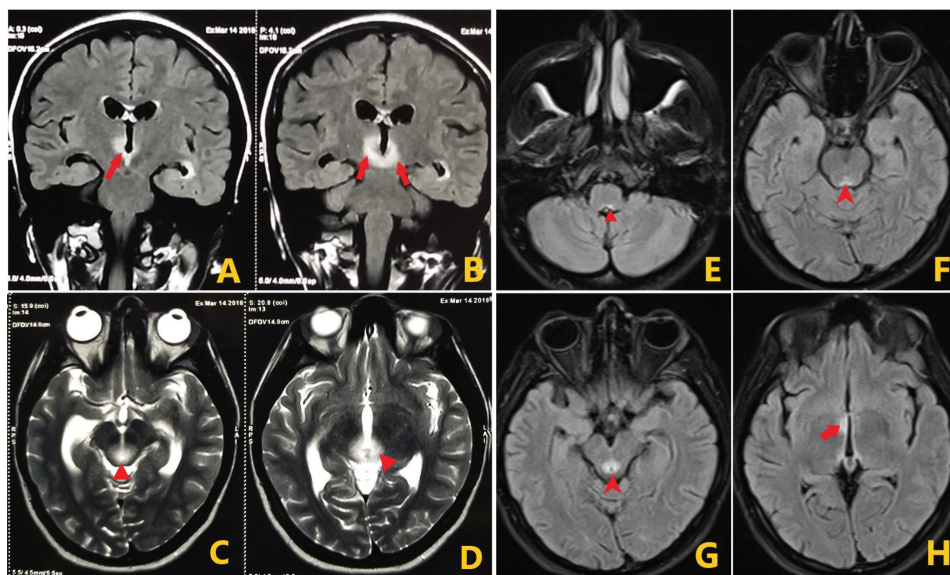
Magnetic resonance images: T2 fluid-attenuated inversion recovery (FLAIR) images (A, B) showing hyperintensities in bilateral dorsomedial thalamus (arrows) and T2-weighted images (C, D) showed hyperintensities in periaqueductal regions (triangular heads). Magnetic resonance images: T2 FLAIR images showing hyperintensities in the area postrema (E) (triangular head) and periaqueductal region (F, G) (arrowheads) and thalamus (H) (arrow).
